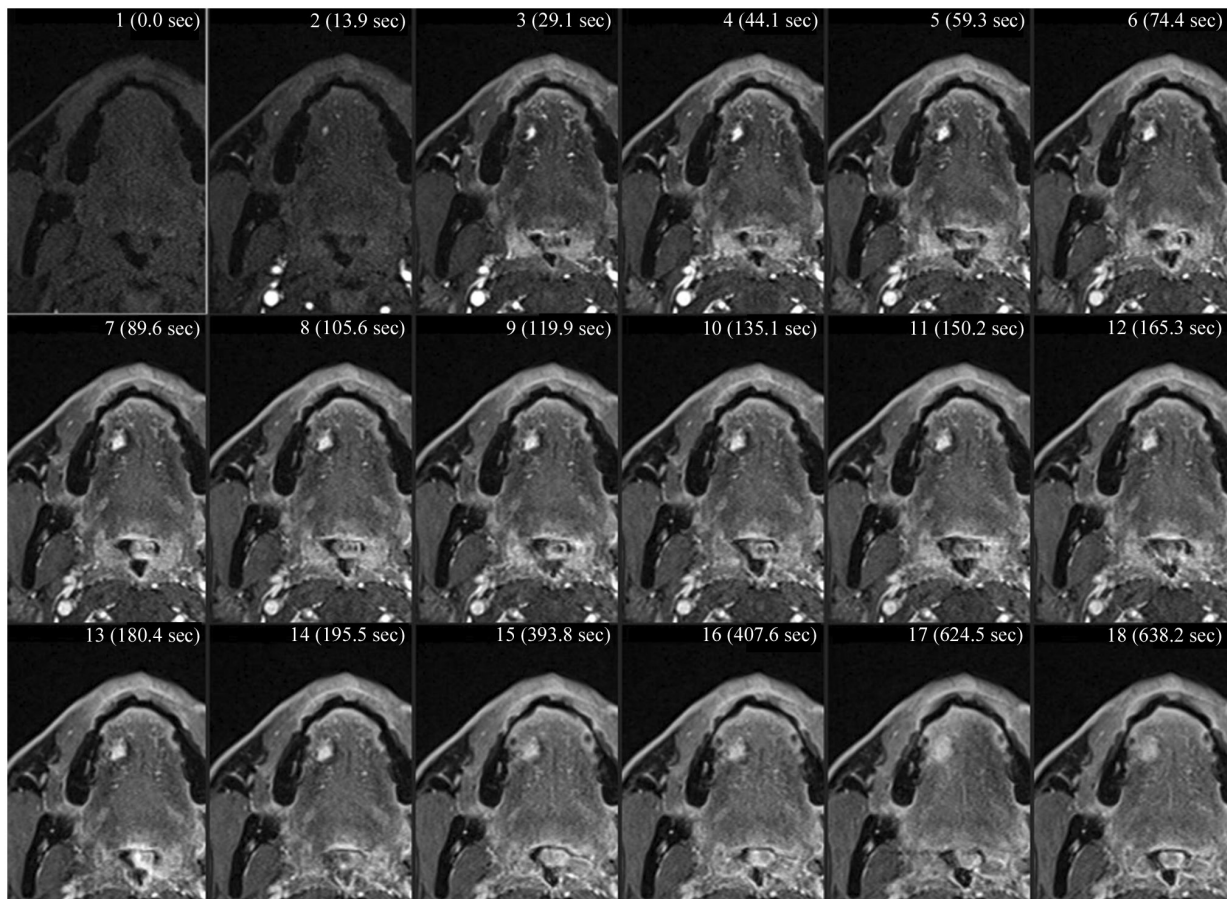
Central enhancement pattern of a vascular anomaly. DCE-MRI images of a vascular anomaly of the right tongue demonstrate gradual enhancement of contrast agent on the central portion of the lesion. DCE-MRI, dynamic contrast-enhanced magnetic resonance imaging.
